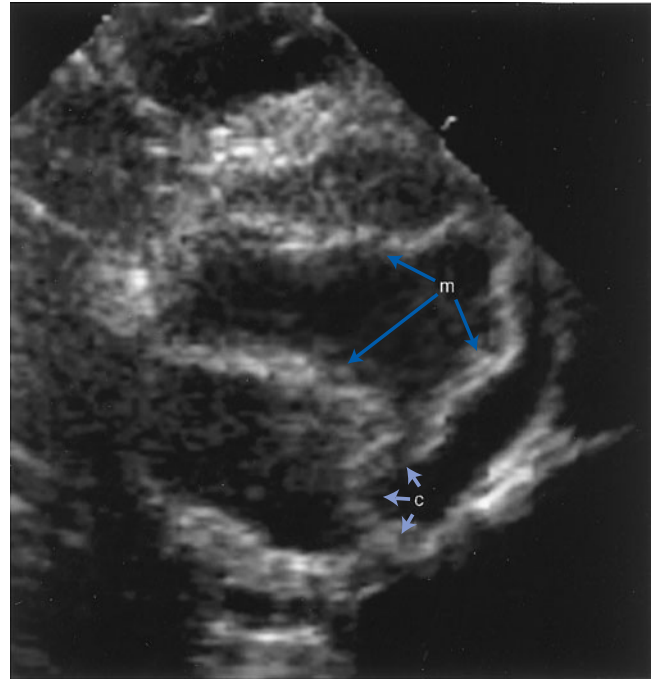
Short-axis echocardiogram of a substitute pulmonary valve in late systole showing the leaflet free margins (m) and absence of reverse bending at the commissures (c).
